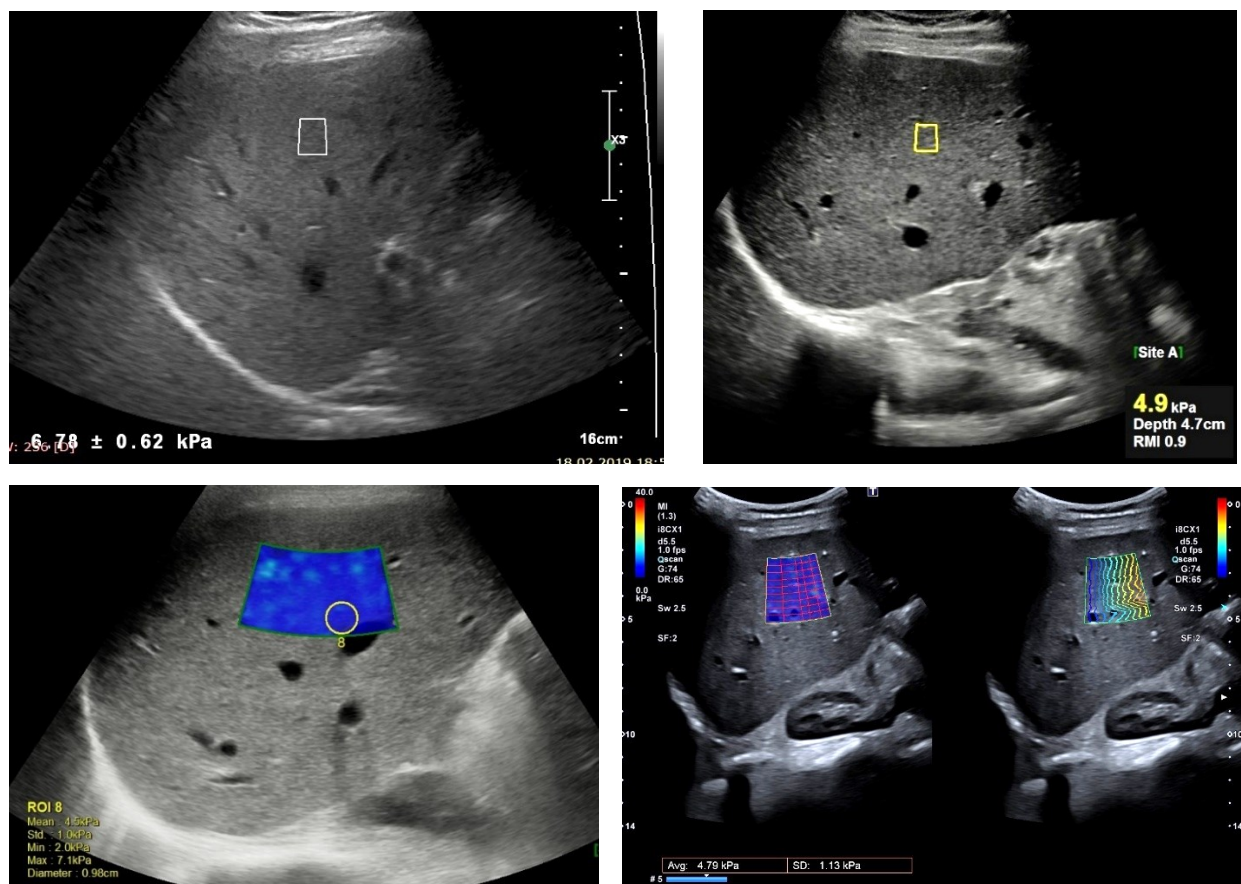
A-D. Ultrasound-Based Elastography for Liver Stiffness Assessment.
